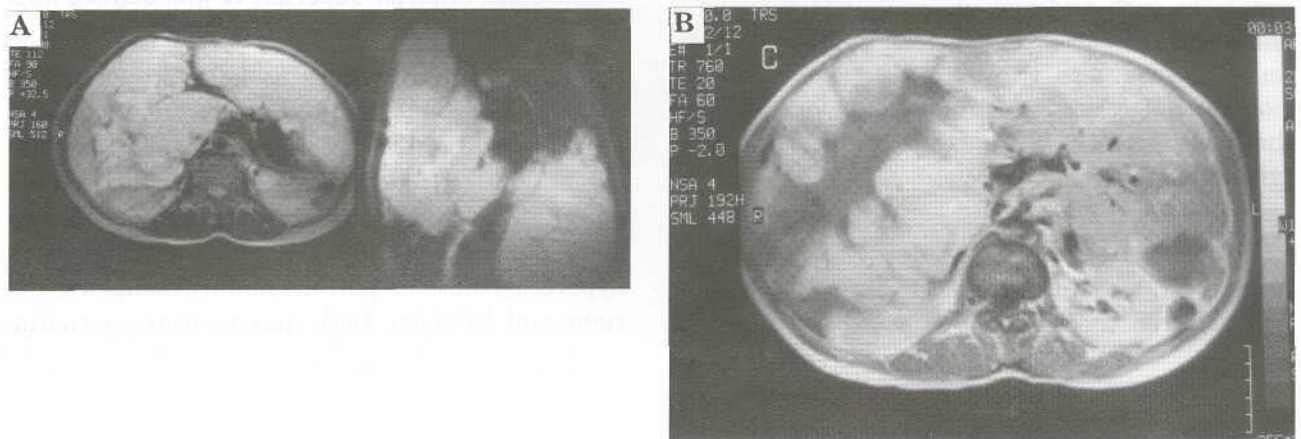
MRI shows two giant masses, 25x14x17 cm in right lobe and 21x17x7 cm in left lobe. Both masses had significantly higher signal intensity in T2-Weighted images (A). In dynamic contrasted examination, masses showed enhancement, which subsequently filled with contrast from the periphery in late images (B).
